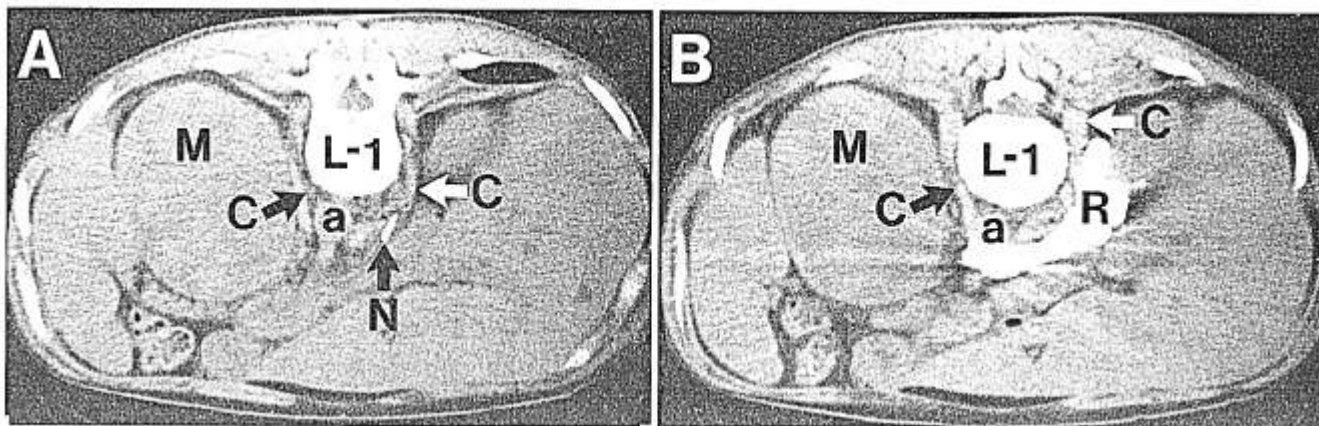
When the transcureal approach is employed, usually only one needle is placed at L1 because, even if computed tomography is used, a needle inserted on the left side would in most instances of necessity pass through the aorta prior to puncturing the crus of the diaphragm, as can be ascertained from the above reproductions of the CT scans. A. Needle's bevel anterior to crus of diaphragm. B. Spread from needle in A of 50 ml of radiopaque material (25 ml of absolute alcohol, 18 ml of 0.75% bupivacaine, and 7 ml of meglumine iohalate USP 60 (600 mg/ml), osmolarity = 1.5 m Osm/ml, that is, Conray). L1 = body of first lumbar vertebra. C = crura of diaphragm. a = aorta. M = massive growth of lung metastasis in left adrenal gland. R = spread of radiopaque solution.
